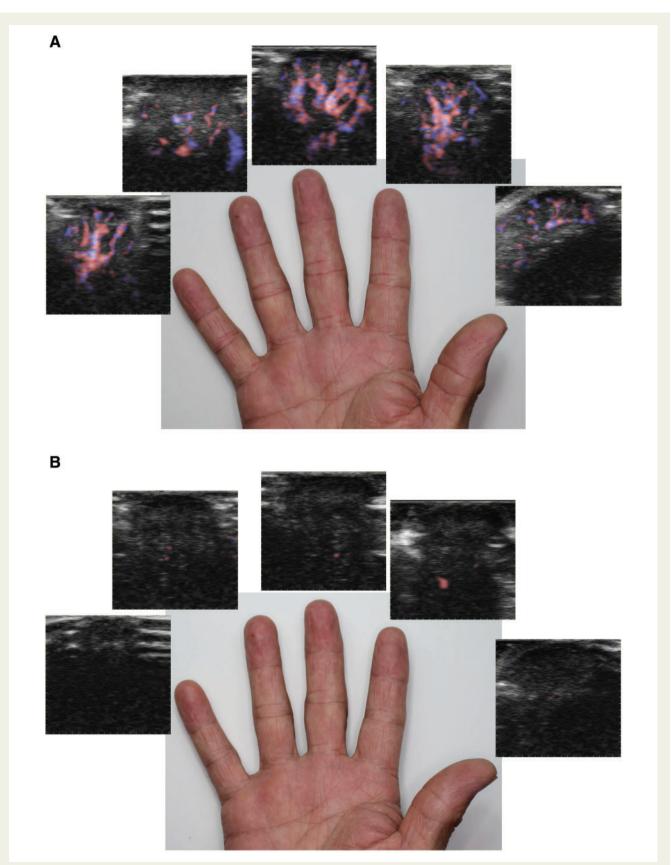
Blood flow in the fingers of the right hand before and after a cold challenge. Before a cold challenge, normal vascularity in the right hand was visualized by a transverse scan of the fingertips (*A*, see Supplementary material online, *Videos S1–S3*, asterisks) using colour Doppler ultrasound. After the cold challenge, vascularity was extremely decreased or was absent (*B*, see Supplementary material online, *Videos S4–S6*, asterisks), whereas there was little difference in skin colour of the hands and fingers before and after the cold challenge (A and B).
